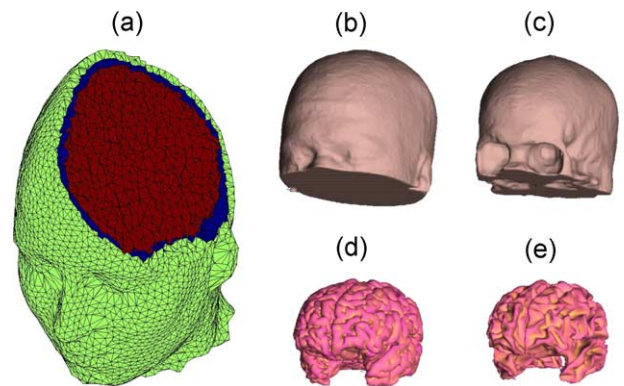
(a) Sample FEM tetrahedral mesh with tissue classification: green = skin, blue = bone, red = CSF or brain. Tessellated surfaces extracted automatically from a T1-weighted MR volume using BrainSuite: (b) scalp, (c) skull, (d) gray matter, and (e) white matter.
